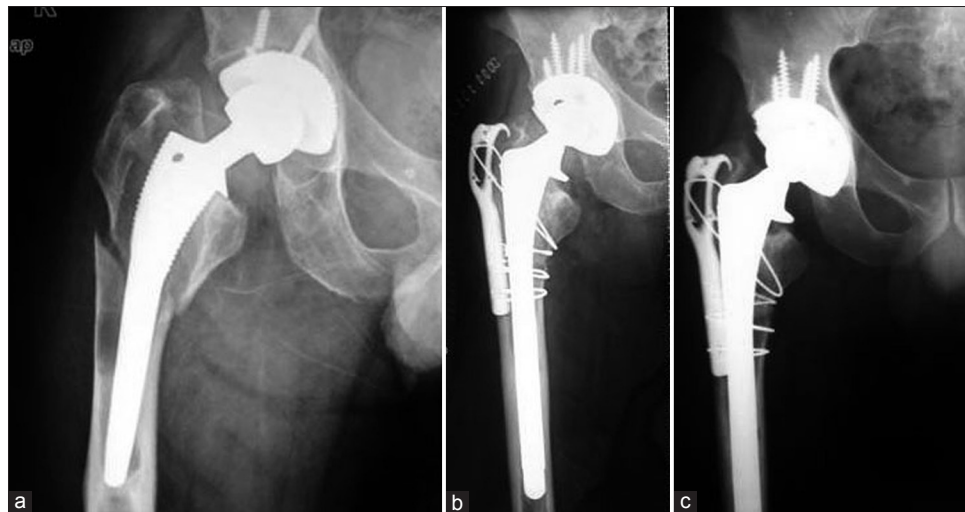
Anteroposterior radiograph of the hip (R) showing (a) periprosthetic femoral fracture, with loosening of the femoral stem and acetabular cup, breakage of screws as well as significant loss of bone mass. (b) The fracture was treated by revision total hip arthroplasty and hook-plate fixation without bone grafting. (c) Bone healing was achieved 16 weeks postoperatively
